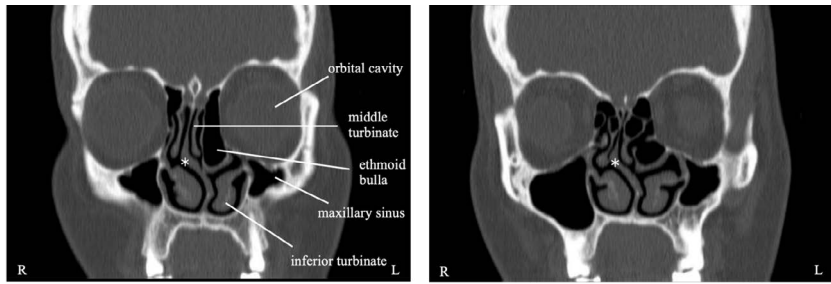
Coronal cuts of non-contrasted computed tomography scan of the paranasal sinuses at the level of anterior ethmoid cavity. The scan shows the pneumatized left ethmoid bulla which causing deviation of the nasal septum (asterisks). The scan also shows left hypoplastic maxillary sinus and bilateral enlarged inferior turbinates. The rest of the paranasal sinuses are clear.
